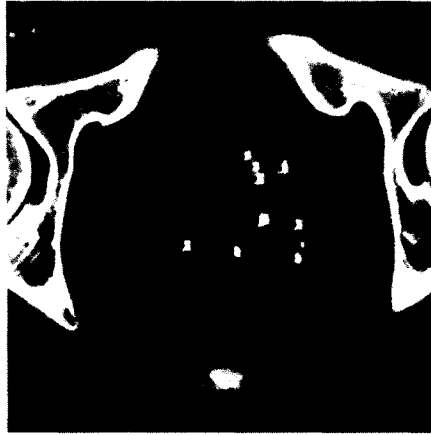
CT slice of a prostate implant near the base of the prostate gland. Note the difference in intensities of structures imaged: bones and implanted seeds appear brightest, air in the rectum darkest.
